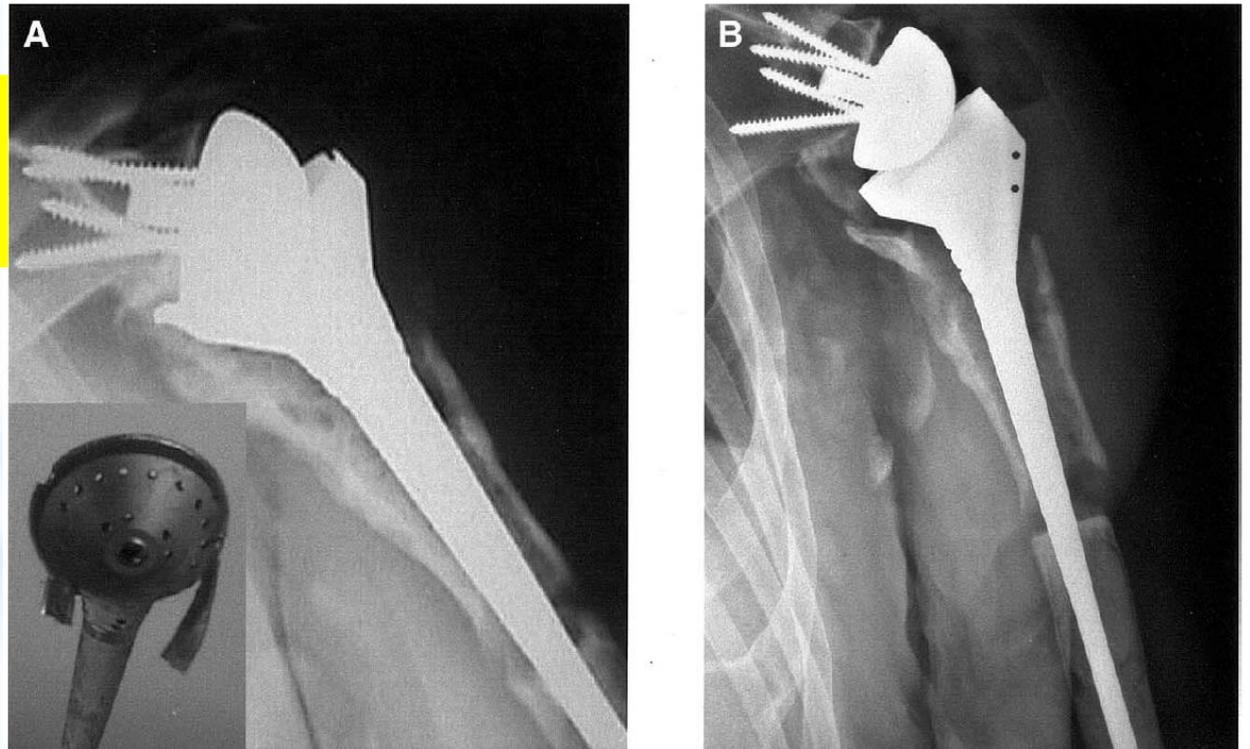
Case 2. A, Epiphyseal prosthetic failure. B, Radiograph at 6 months after surgery showing resorption of bone grafts.
